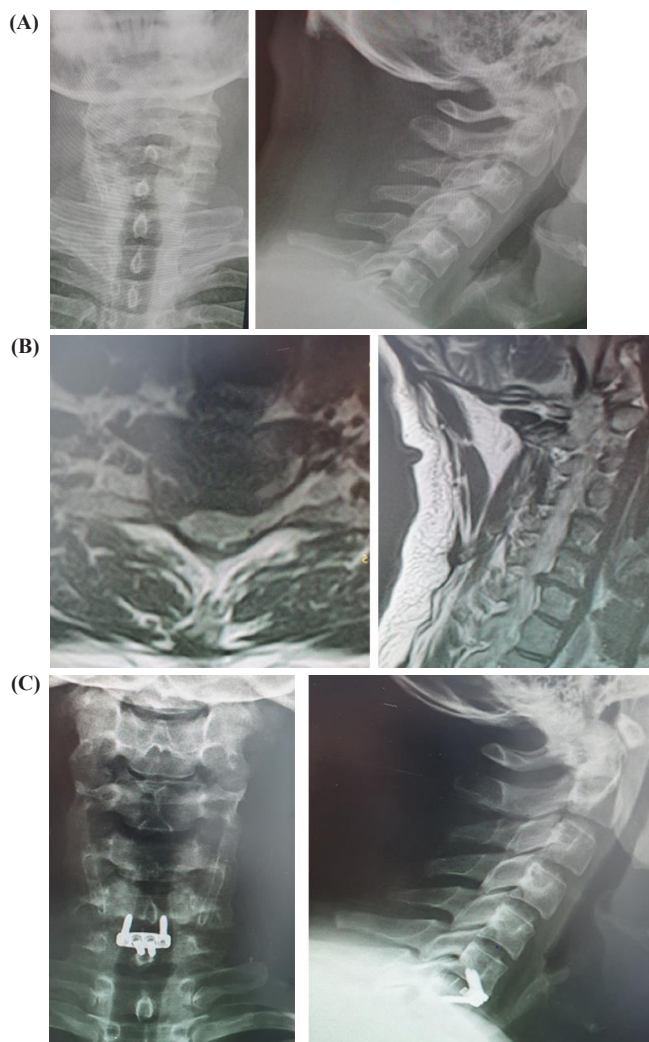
Forty five years old male C/O neck pain and brachialgia due to C6-7 disc herniation, C6-7 anterior cervical discectomy and fusion was done with Zero-P implant. (A) Preoperative plain radiographs (B) Preoperative MRI (C) Postoperative plain radiograph at final follow up.
